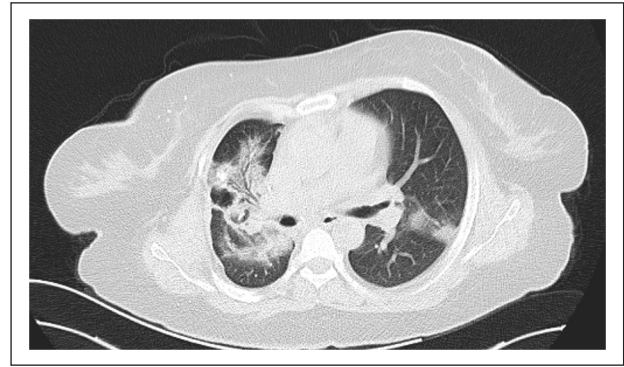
Thoracic CT scan of the patient when admitted to the hospital. The lesions are indicated as highly suspicious for COVID-19.
